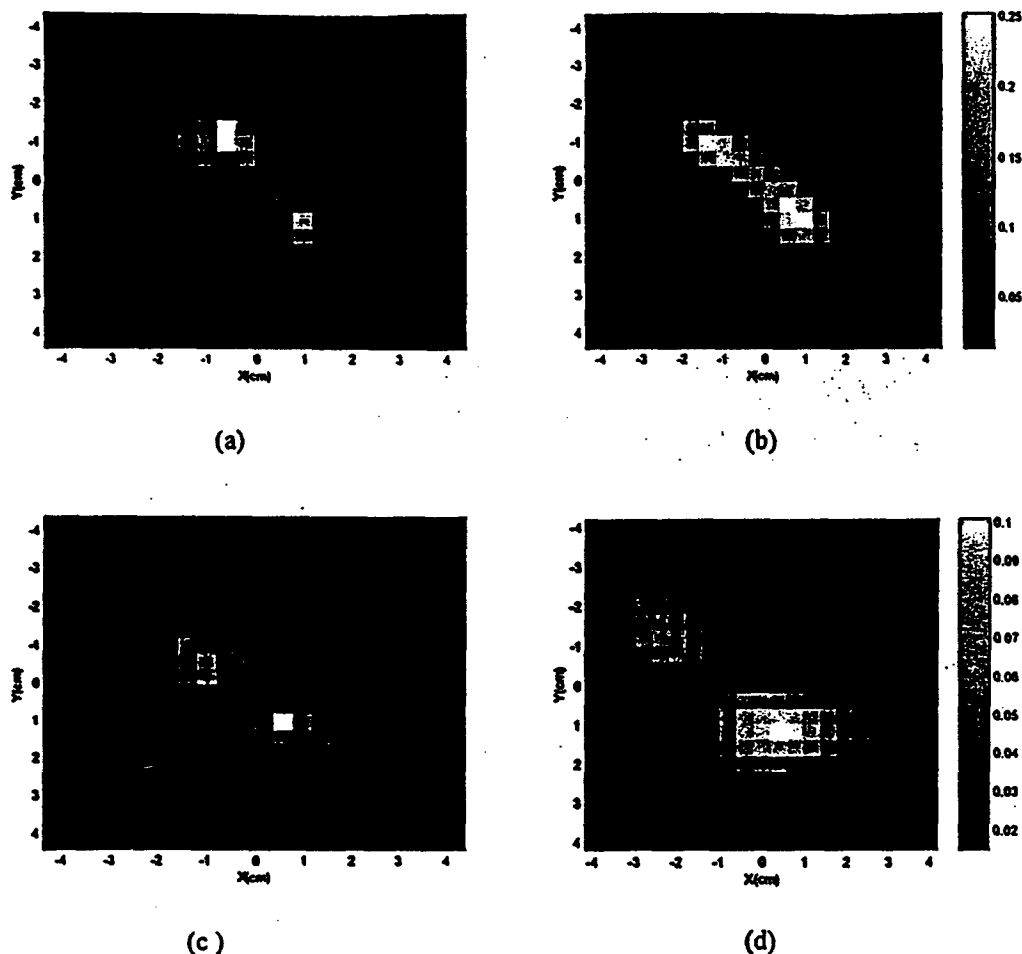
Simultaneously obtained ultrasound and NIR absorption images. The fitted background μ_a and μ_s' are 0.017 and 4.90 cm^{-1} , respectively. (a) Ultrasound and (b) NIR absorption image of two high-contrast targets (target $\mu_a = 0.25 \text{ cm}^{-1}$). (c) Ultrasound and (d) NIR image of two low-contrast targets (target $\mu_a = 0.10 \text{ cm}^{-1}$). In both high- and low-contrast cases, the two targets were located at 2.5 cm in depth.
